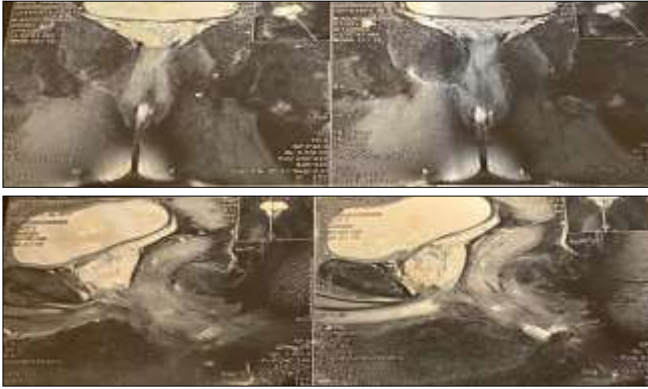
Pus formation around the Pubic Symphysis and Retropubic Space on Contrast Enhanced Magnetic Resonance Imaging (CEMRI)
